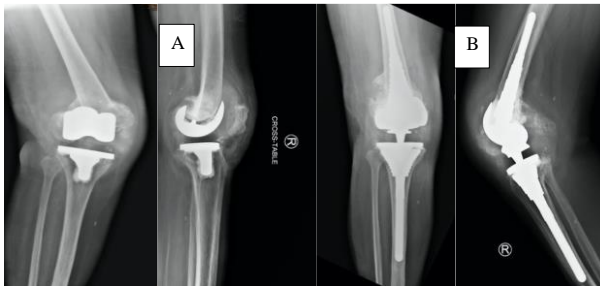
(A) Preoperative radiographs showing the supracondylar periprosthetic fracture with insufficiency of the medial collateral ligament. (B) Radiographs taken after implantation of an S-ROM rotating-hinge knee prosthesis (DePuy Orthopedics) confirming favorable composition.
